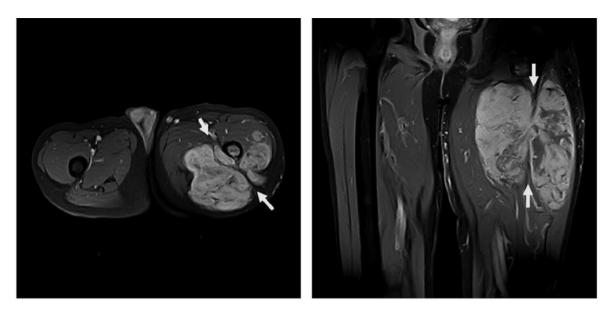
Magnetic resonance imaging revealed a mass extending into the anterior compartment in the patient's thigh beyond the intermuscular septum (arrows).
